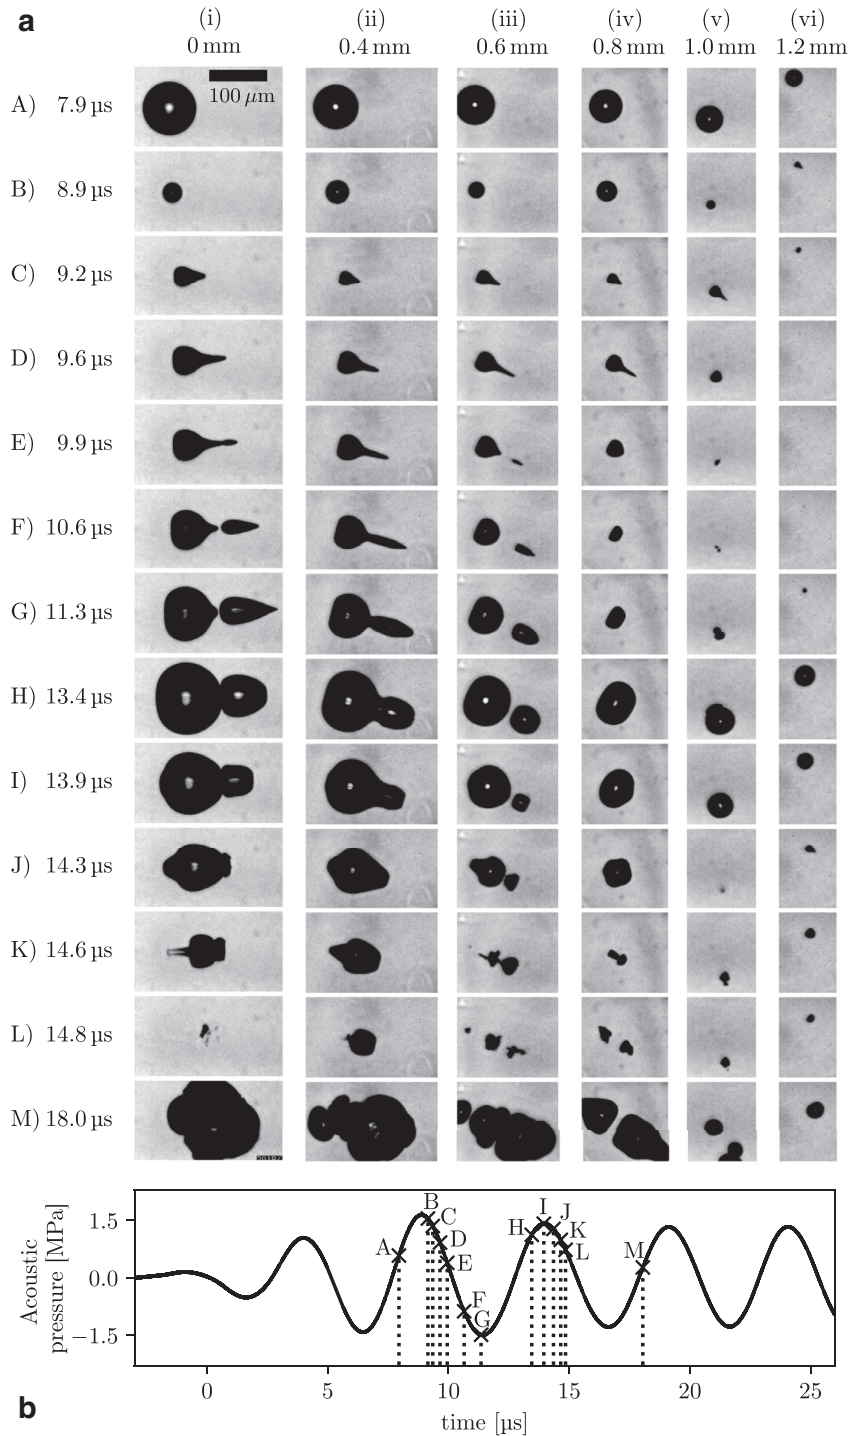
(a-i-vi) Representative images from side view imaging sequences, capturing microbubble cavitation activity from the first significant inflation, over the two subsequent cycles of focused ultrasound, at various lateral offset distances from the propagation axis. (b) An on-axis needle hydrophone measurement of the first cycles of the focused ultrasound burst (over the duration of side view imaging), at a peak negative pressure of 1.5 MPa.
